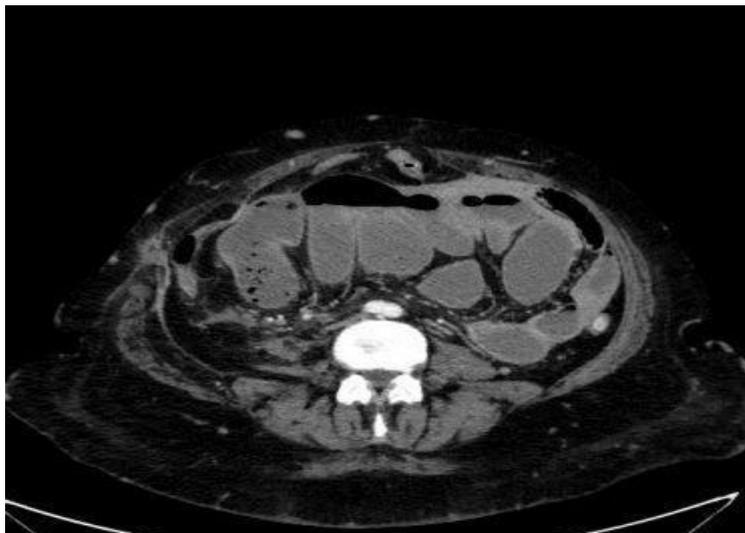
The abdominal CT scan showing cluster of collected dilated small bowel loops seen in the center of abdominal cavity, which are apparently enclosed within a sac like membrane that showed foci of calcification in its anterior wall with multiple mesenteric and retroperitoneal sub centimetric lymph nodes. There was no evidence of free fluid or air intra peritoneally.
